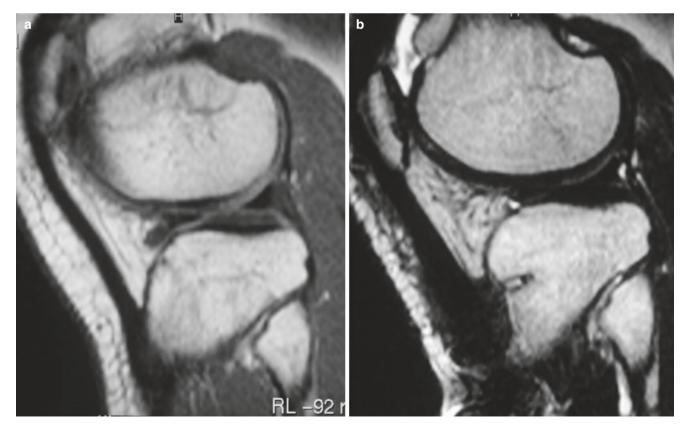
(a, b) Pre- and postoperative MRI showing length modification of the patellar tendon
